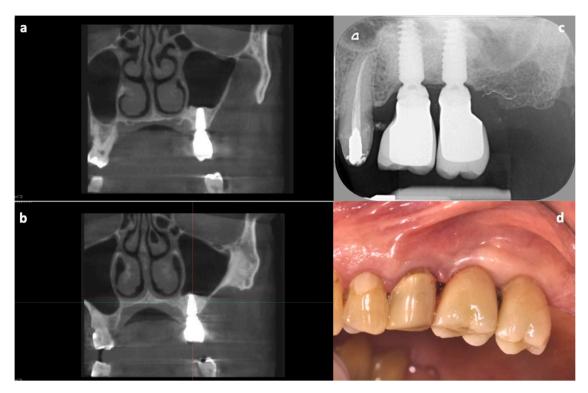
Postoperative radiological [CBCT exam using implants as reference (a, b), and endoral x-ray (c)] and clinical images at 7-year follow-up (d).
